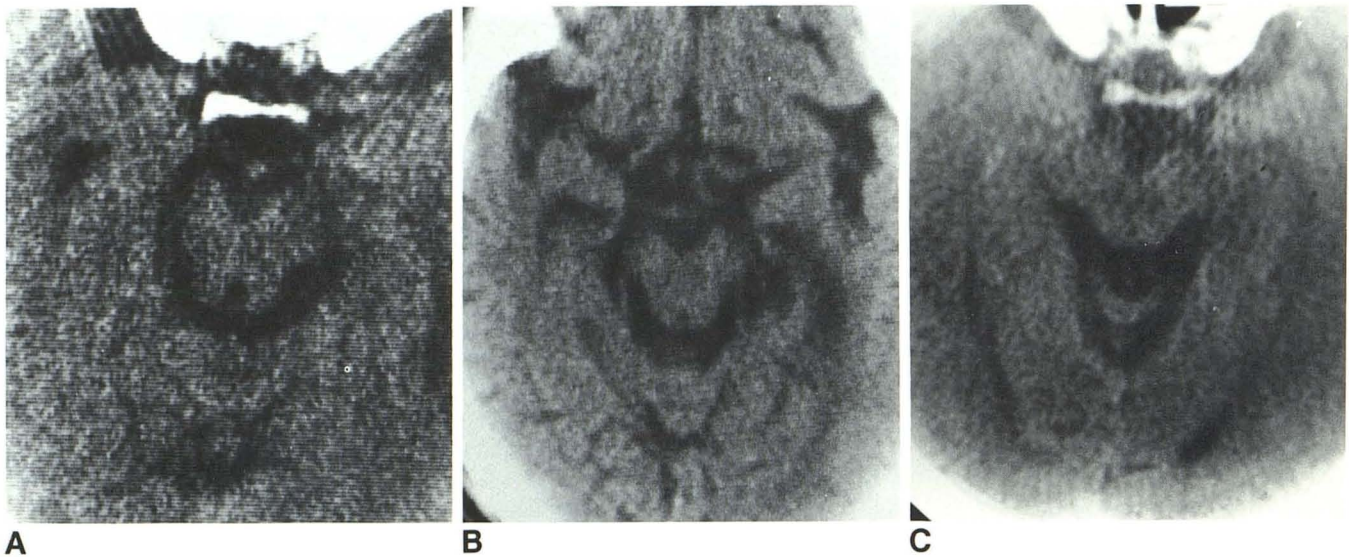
Cases 3 (A), 6 (B), and 7 (C). CT sections through midbrain. Atrophy (small midbrain), enlarged quadrigeminal and interpeduncular cisterns, and dilated aqueducts in cases 3 and 6.
